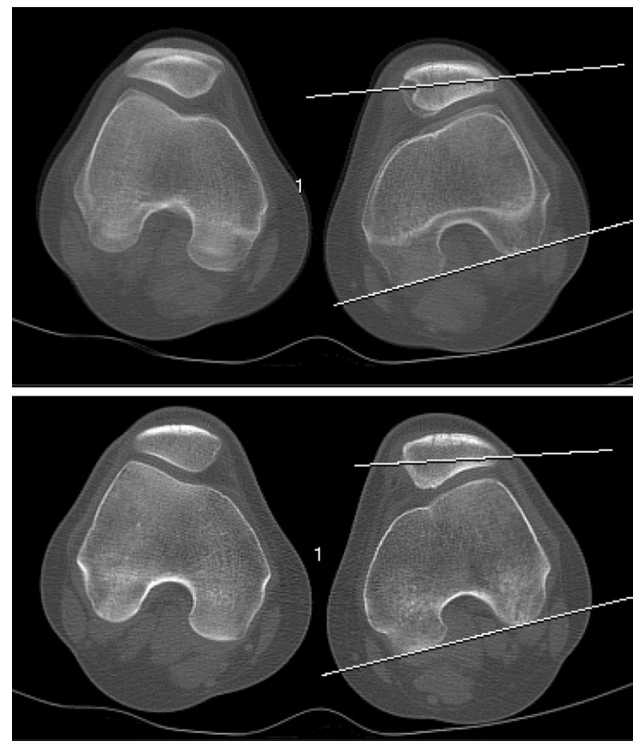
Preoperative CT scan and final follow-up
